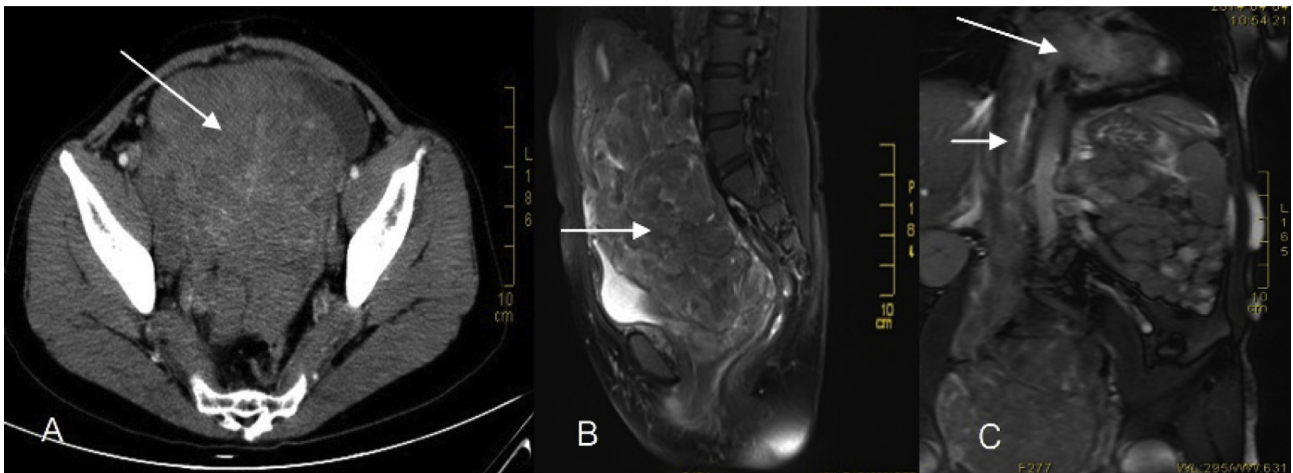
(A) Pelvic computed tomographic image showing a huge pelvic mass. (B) Magnetic resonance image (MRI) showing the uterus and mass. (C) MRI showing the masses in the inferior vena cava and right atrium.
